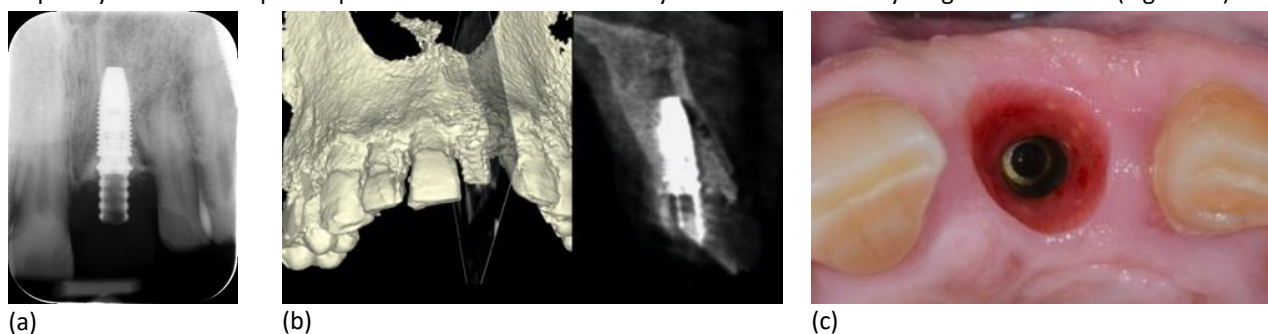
Patient 2: (a) Post OP dental x-ray shows implant & provisional crown with cerabone® particles on lateral sides; (b) Post OP CBCT shows cross sectional aspect of implant position, saved vestibular bone plate and defect filled with bone substitute; (c) Final soft tissue contour after four months shows nice emergence profile in its circumference and in its height.
